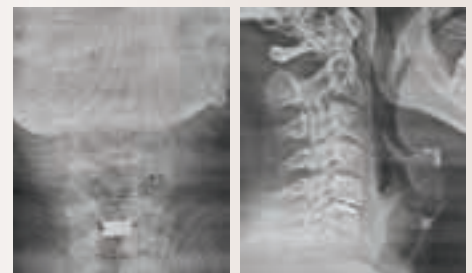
Model depicting (a) the Mobi-C prosthesis, made of metal end plates and a plastic core or center, and (b) X-rays with the prosthesis after recent surgical insertion.
